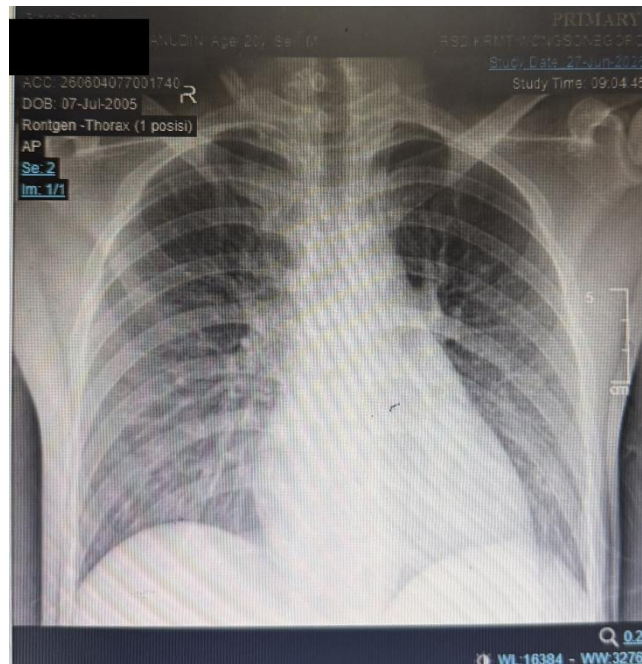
AP Thoracic X-ray Photos Show Increased Pulmonary Vascular Patterns and Bilateral Perihilar Infiltrates Leading to Bronchopneumonia (patient identity has been disguised)
